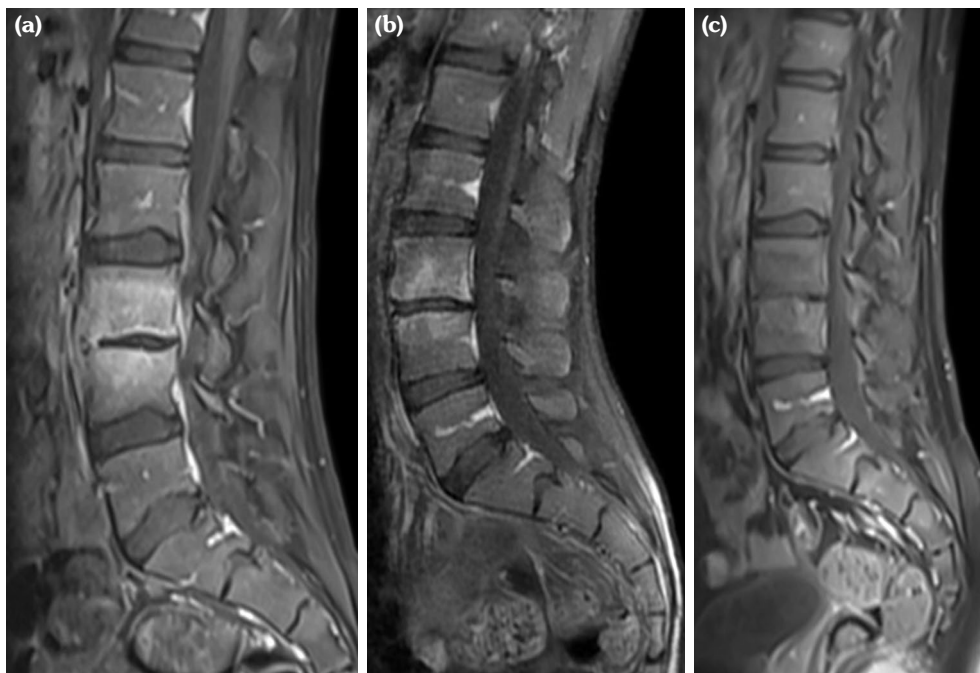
(a, b and c) Images show follow-up magnetic resonance imaging scans at approximately seven months. Sagittal enhanced T1A sequences show a decreased contrast uptake, edema and T2W hyperintensity over time (regression in radiological findings). Differential diagnosis includes malignant tumors such as lymphoma and cancers, infective and inflammatory disease and early stage Langerhans cell histiocytosis. In follow-up, due to regression in radiological findings, malign and infective diseases were excluded and further inflammatory diseases were considered.
